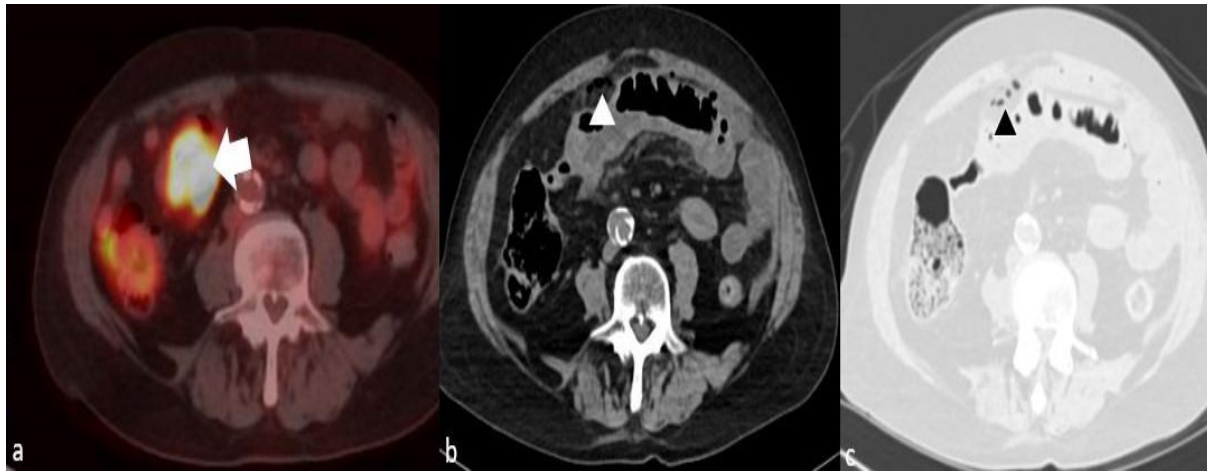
(a) Axial PET-CT image demonstrates intense FDG uptake within a necrotic mass located in the distal ileal segment (white arrow). (b) Axial non-contrast-enhanced abdominal CT reveals free air (white triangle) adjacent to the tumor, indicative of perforation. (c) Axial lung window image of the non-contrast CT more clearly visualizes the free air (black triangle).
